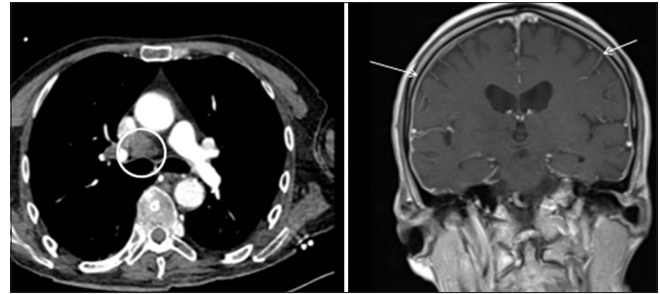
Axial contrast-enhanced computed tomography demonstrates enlarged mediastinal nodes. Coronal-enhanced MR brain shows diffuse pachymeningeal thickening (white arrows).
